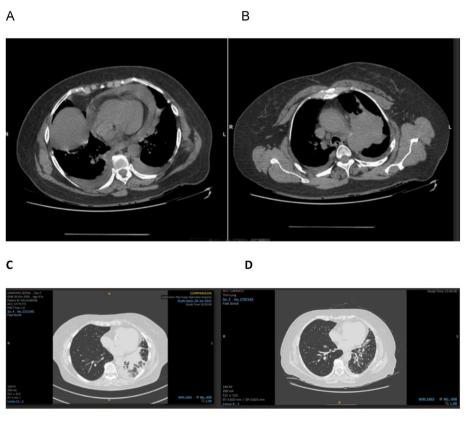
(A) Computed Tomography (CT) imaging (Dec 2020) showing pericardial effusion. (B) Computed Tomography (CT) imaging (Dec 2020) showing left lung mass. (C) Chest High-Resolution Computed Tomography (HRCT) (July 2023) demonstrates evidence of disease progression following chemotherapy. (D) Follow up Chest High-Resolution Computed Tomography (HRCT) (Aug 2023) showing a rapid response to Gefitinib.
